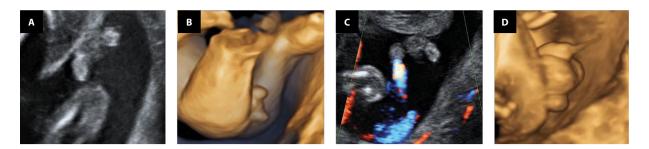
A clinical, sonographic approach to a fetal perineal lump. The target sign was visualized at the posterior perineal triangle; A. 2D midsagittal view demonstrating the scrotum and upper and lower findings that resemble a male phallus (*); B. 3D rendering of the fetal perineum demonstrating the findings described in A; C. Doppler flow demonstrates urination from the upper mass, i.e., the penis, while no flow is demonstrated originating from the lower mass; D. 3D rendering demonstrating fetal urination as described in; the final diagnosis was a perineal lipoma
